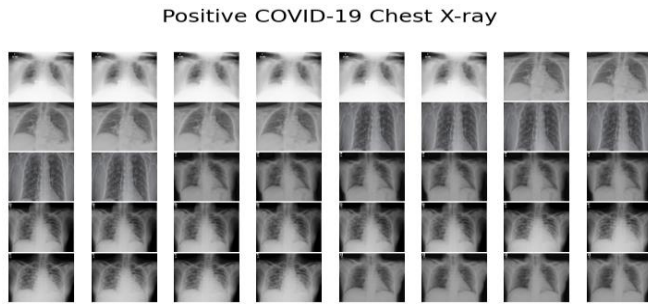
Covid-19 Negative and Positive chest X-ray
